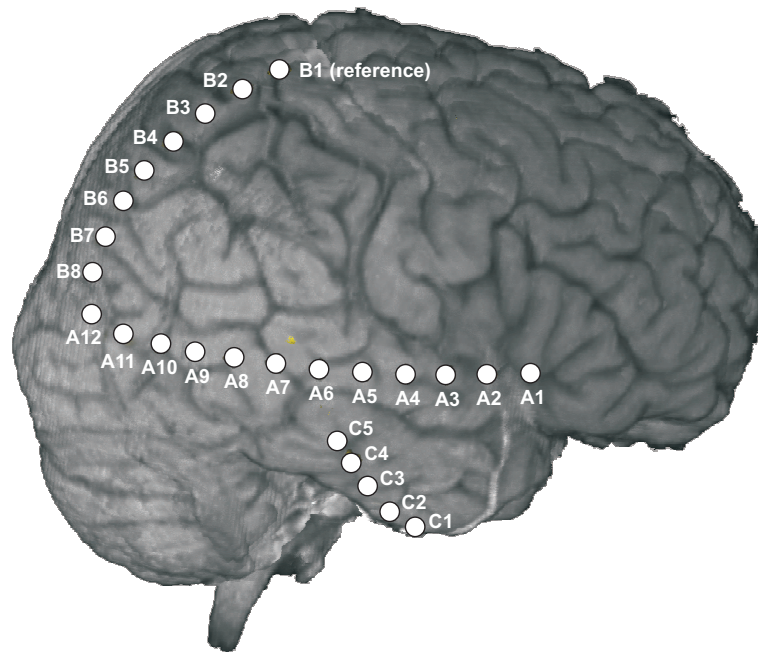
MRI picture of the brain including the electrode positions.
